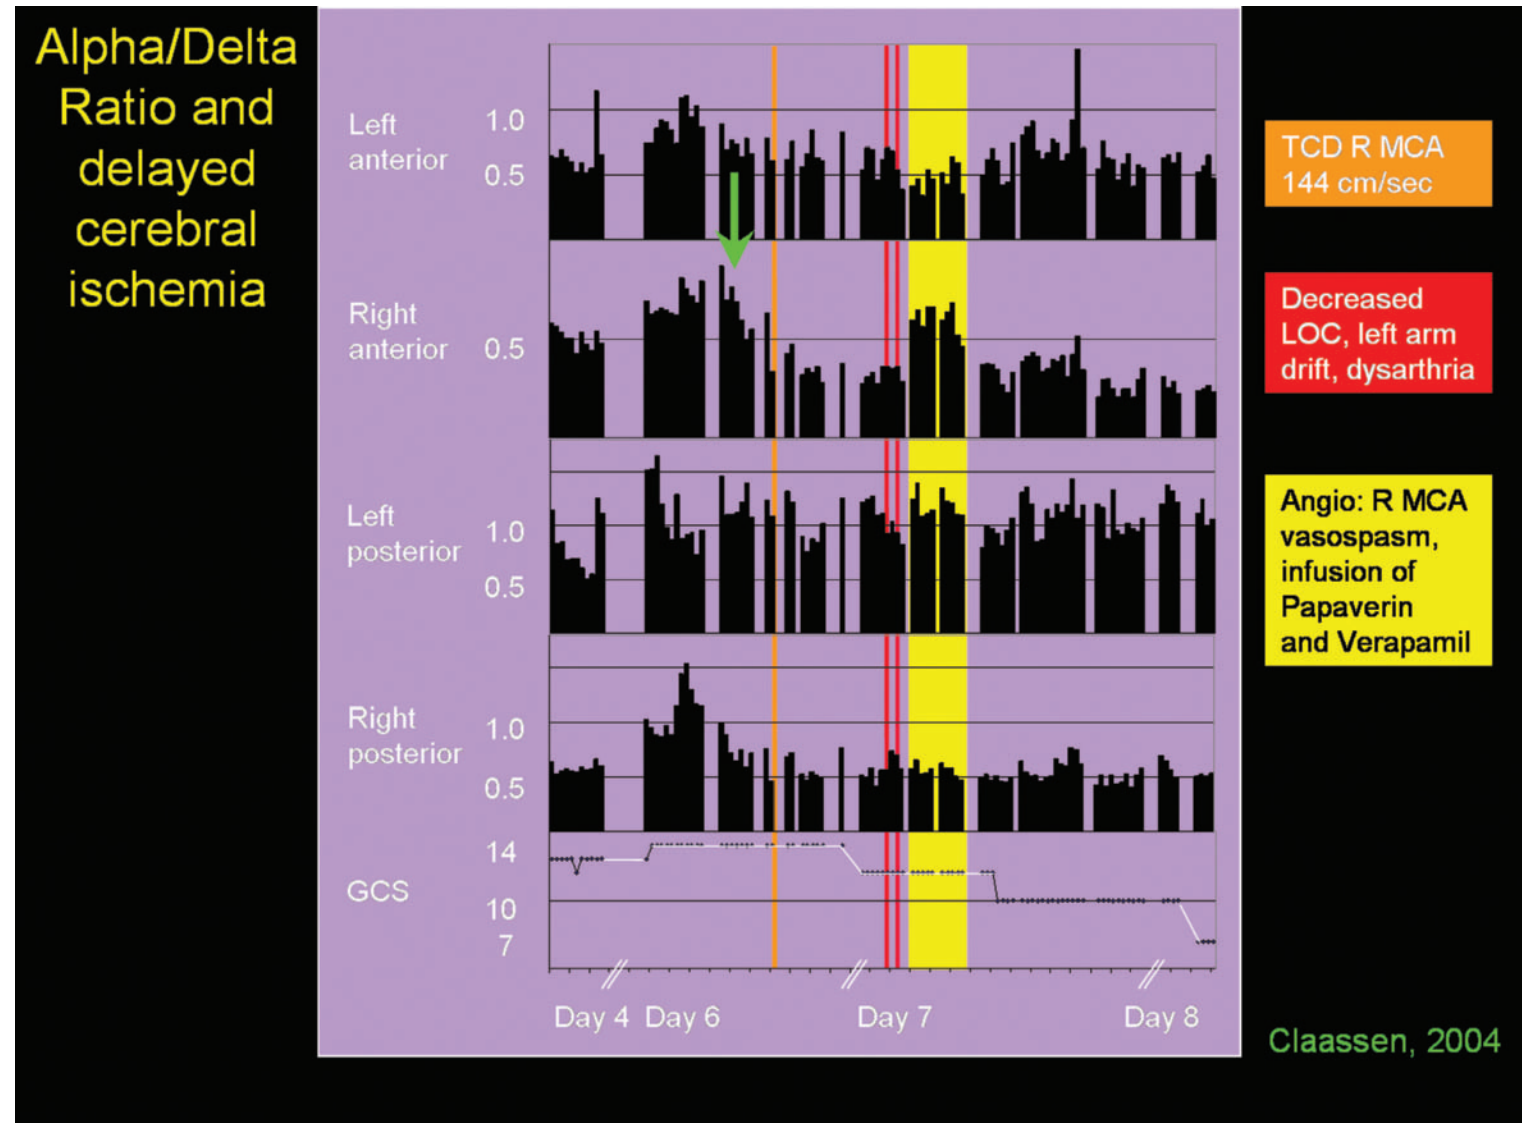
Multimodality monitoring for vasospasm after subarachnoid hemorrhage (SAH); alpha–delta ratio. Main: Alpha–delta ratio (ADR) calculated every 15 min and Glasgow Coma Score (GCS) shown for days 6–8 of continuous EEG (cEEG) monitoring. A 57-year-old woman admitted for acute subarachnoid hemorrhage (admission Hunt–Hess grade 4) from a right posterior communicating aneurysm. Admission angiography did not show vasospasm. The aneurysm was clipped on SAH day 2. No infarcts were seen on postoperative CT, day 2 (shown on next page). Postoperatively she had a GCS of 14. CEEG monitoring was performed from SAH
